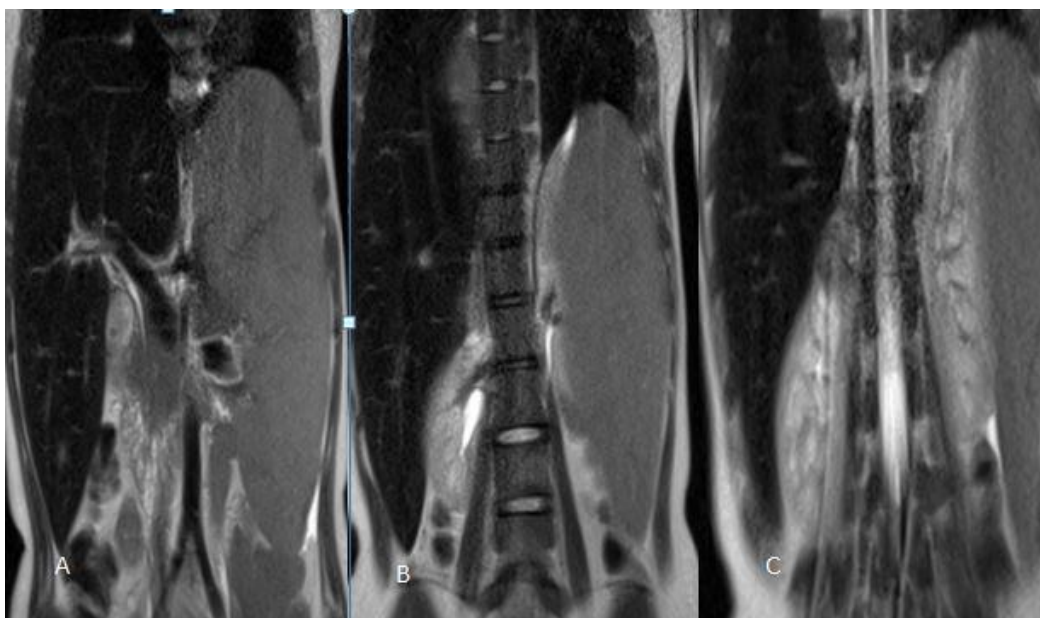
MRI Abdomen (Coronal T2)- A-showing hepato-splenomegaly with markedly hypointense liver, B- showing right paraspinal lesion, C- showing well defined right suprarenal mass.
